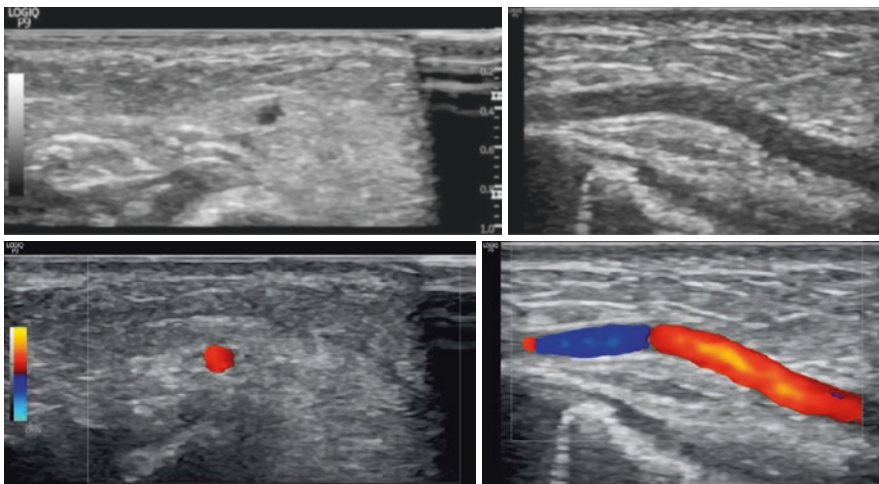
2D image and color doppler of the radial artery in short and long axis views
